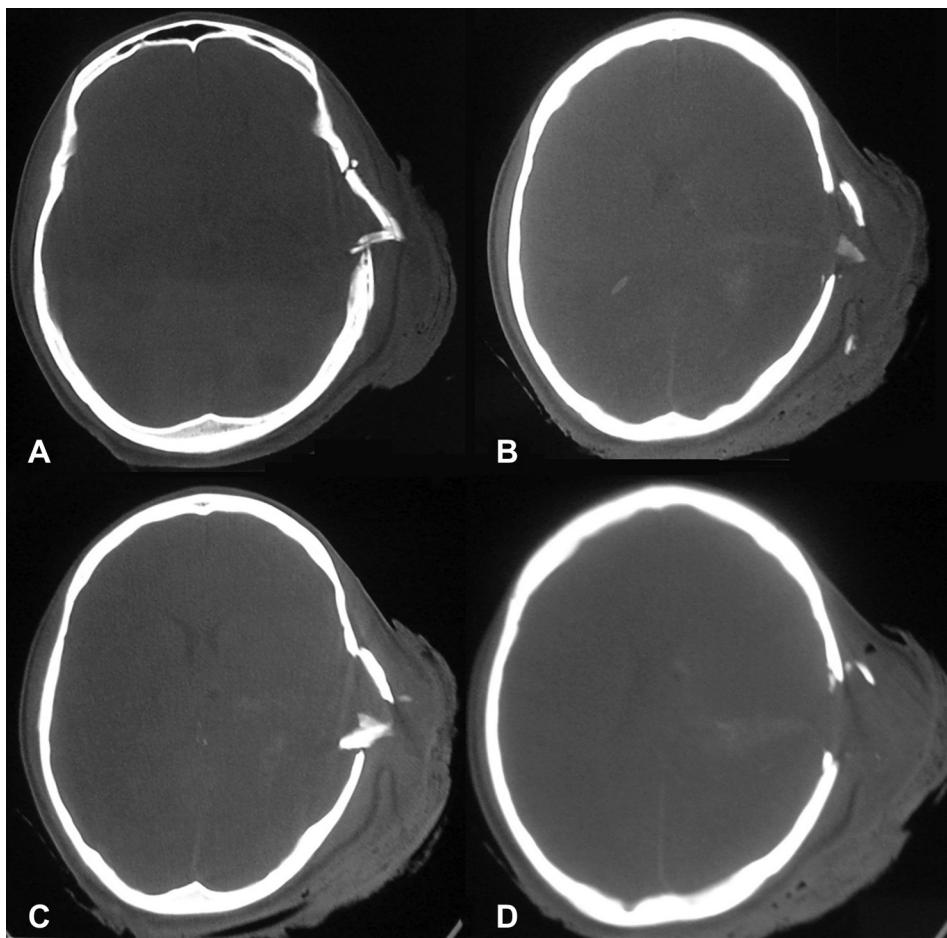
CT scan brain bone window showing extensive scalp swelling and elevated bone fragments.
